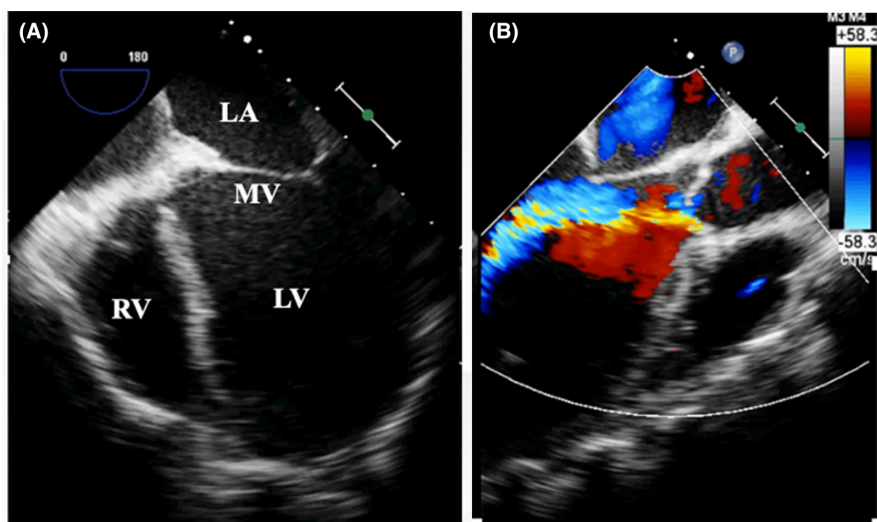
Transesophageal echocardiography. Findings include a dilated left ventricle, severely impaired cardiac function (A), and aortic regurgitation (B); left ventricular ejection fraction (LVEF) is 20%–30%.
